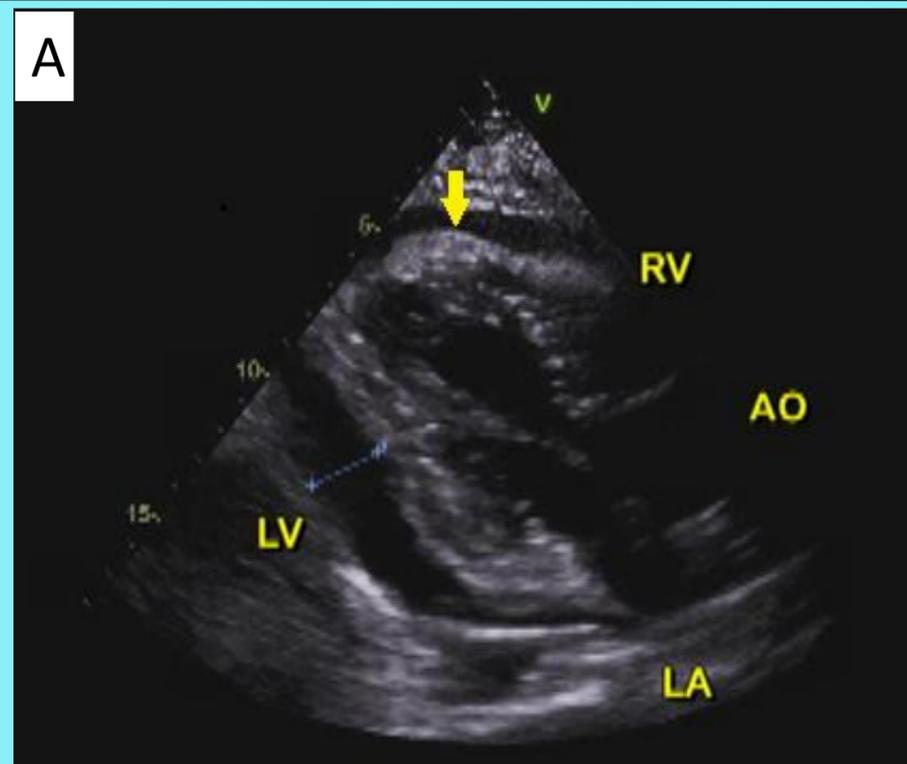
Figure A, B. Two-dimensional transthoracic echocardiography in long axis view. A. The area of the right ventricular with the overlying fibrin (arrow) before intrapericardial injection of fibrinolytic agent. B. Following injection, with reduction of the in size of echogenic fibrinous material overlying the right ventricle. AO= aorta; LA= left atrium; LV=left ventricle; RA= right atrium; RV= right ventricle.
